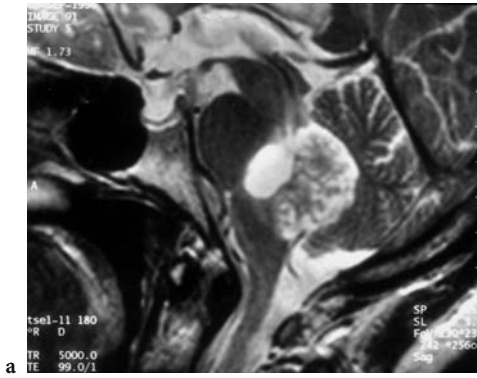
A 51-year-old man with right NIII and bilateral NVI paresis. Diagnosis: plexus papilloma of the fourth ventricle. MRI: a Midsagittal T2-weighted image showing a tumor occupying the entire fourth ventricle. The apparently solid tumor part with irregular signal intensity is surrounded by a CSF-equivalent signal, while a ventral cyst depresses and infiltrates the rhombencephalon. Note ventral depression of the cerebellar vermis and the flow void in the aqueduct. b Corresponding T1-weighted native image showing the intraventricular location of the solid tumor part. Note widening of the roof of the fourth ventricle with open aqueduct, better seen than in the T2-weighted image. c Axial T1-weighted, contrast-enhanced view, demonstrating homogeneous signal enhancement of the solid tumor part. The cyst should not be mistaken for the fourth ventricle of which the remnant is seen posteriorly (*white arrow*). (With permission of Dr. Müller-Forell, Institute of Neuroradiology, Medical School, Mainz)
